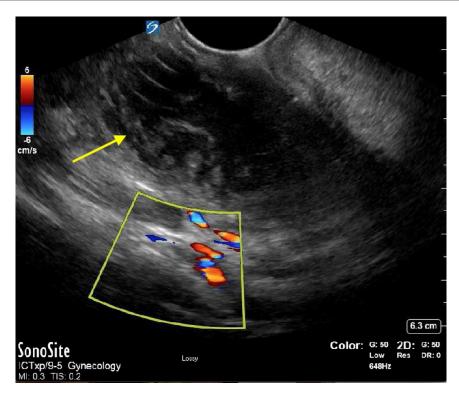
Point-of-care ultrasound with endocavitary probe demonstrating swirling echogenic debris encapsulated approximately 3 centimeters deep, representing initial abscess (arrow). Color box represents vasculature, including carotid artery.
